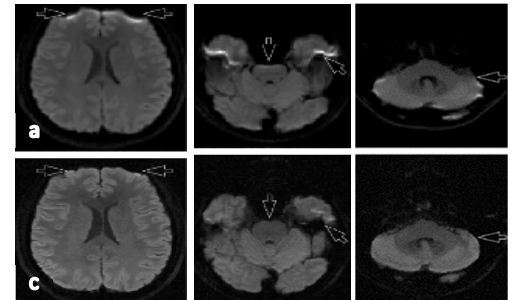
Comparison of DWI data obtained with a) conventional single-shot parallel EPI (2x2x3mm) and c) newly developed navigated-MUSE method (0.8x0.8x3mm)
